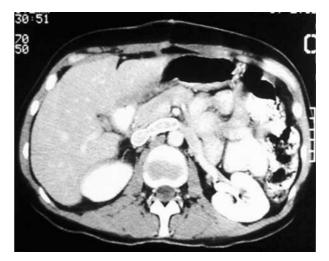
Abdominal CT scan demonstrating the patent e-PTFE inferior vena cava graft with the side graft from the left renal vein and the directly implanted right renal vein.
